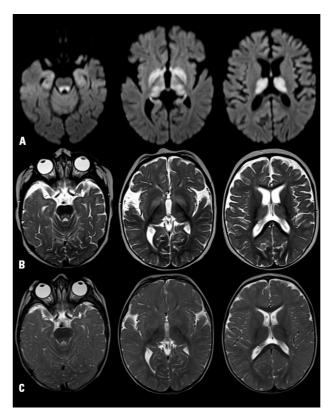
Row A shows initial MRI scan with restricted diffusion – high DWI signal (low signal in ADC map not shown) – in the dorsal brain stem, in the globus pallidi and in the thalami. Row B is the corresponding T2 weighted initial scan. Row C shows signal normalization on T2 weighted images three months after discontinuation of vigabatrin (diffusion imaging also normalized, not shown).
